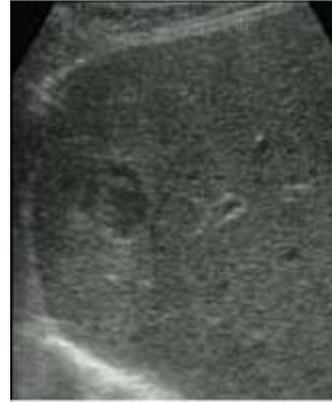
Ultrasound abdomen showing liver abscess
